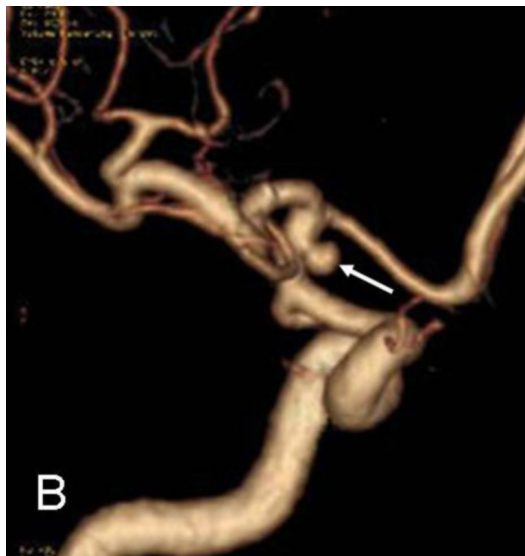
63-year-old female with anterior-wall aneurysm of the ICA. Followup angiogram and 3D-CTA after treatment. Angiogram two months after the treatment (A) shows no aneurysm (arrow), but it is clear on 3D-CTA (B, arrow).
